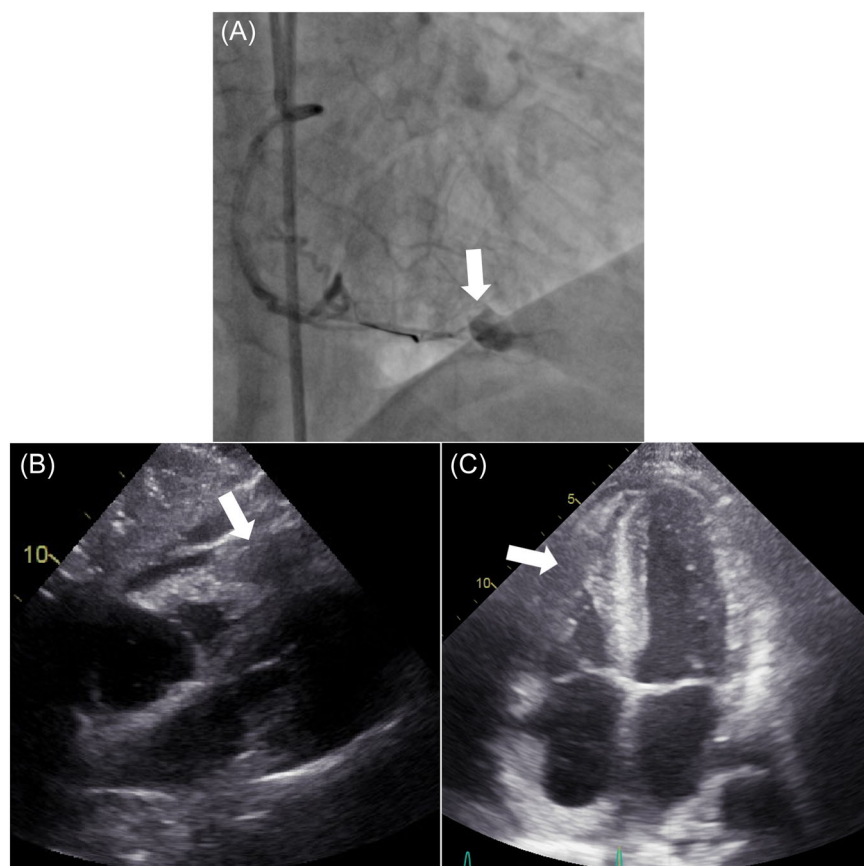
(A) Postprocedural angiogram revealing contrast extravasation from the distal PDA indicating coronary perforation. Subcostal (B) and apical (C) echocardiographic views showing the right ventricular wall hematoma.
